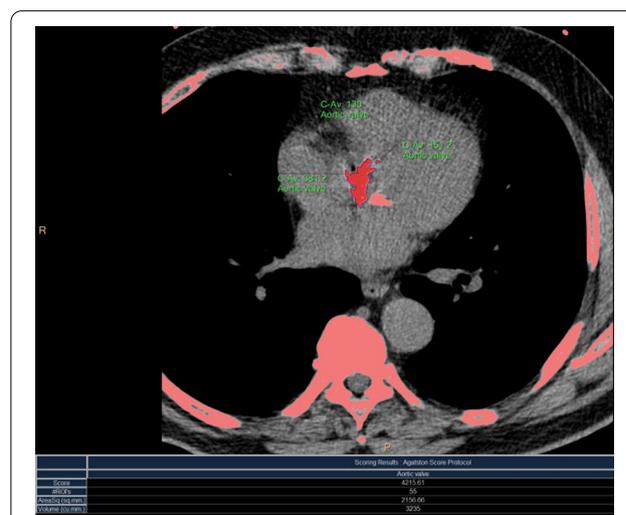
Calculation of the CT calcium score for the aortic valve showing Agatston score = 4215
